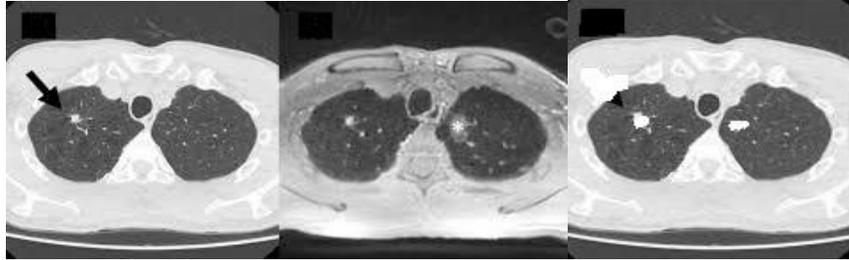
a) CT scan image of lungs b) MRI image of same lungs c) Fused image of CT and MRI
